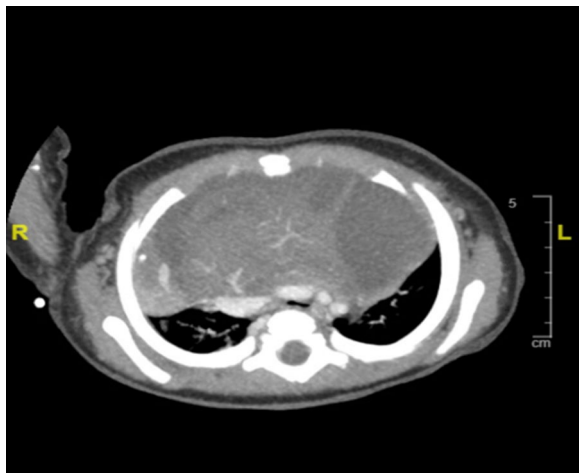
Cross-section computed tomography (CT) showing large anterior mediastinal mass (AMM)
